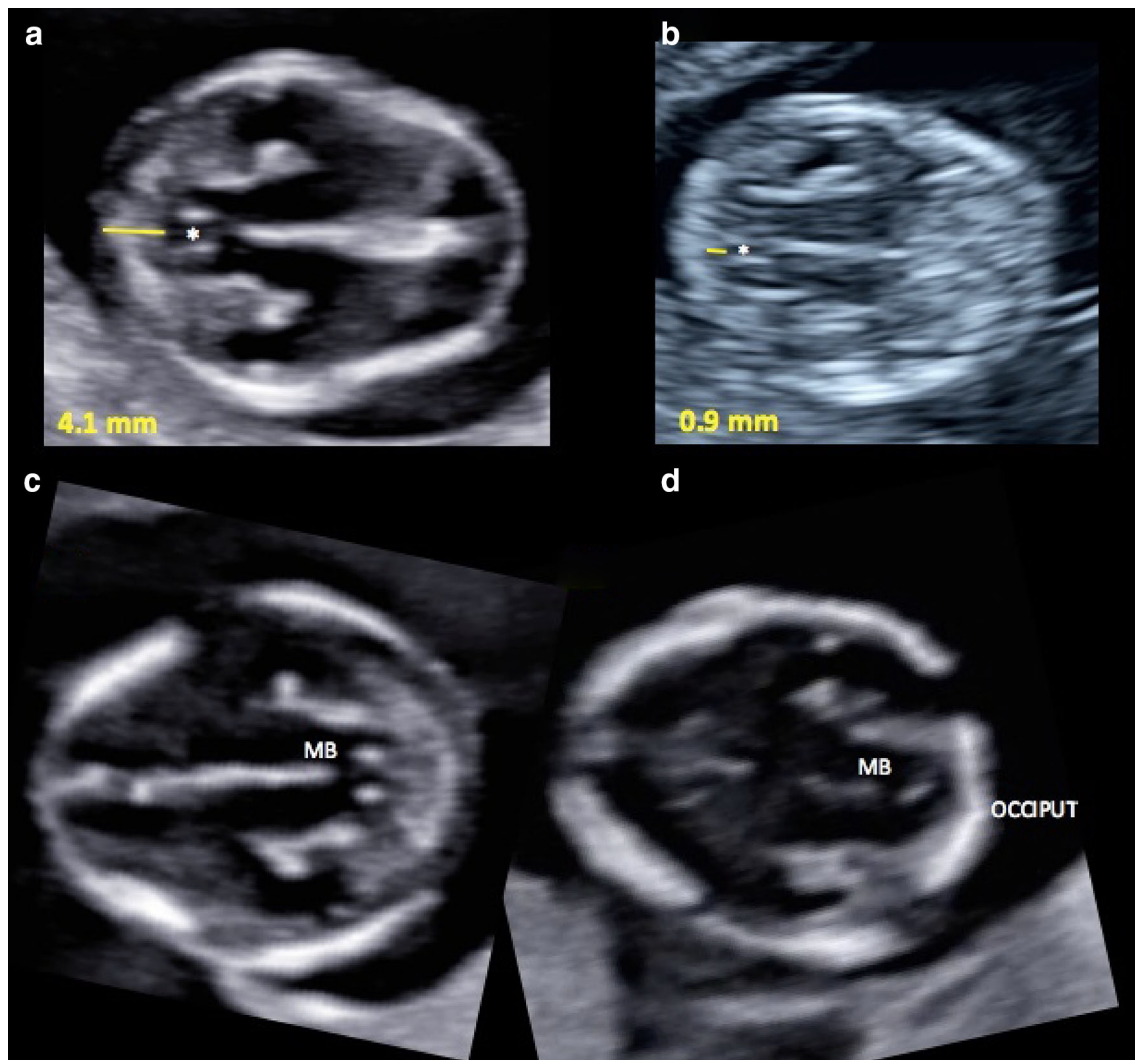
a Aqueduct of Sylvius (AOS)—occiput distance. Axial transabdominal sonogram of head shows normal distance between AOS (*) and occipital bone in a fetus of CRL 68 mm, b Aqueduct of Sylvius (AOS)—occiput distance. Axial image shows reduction in AOS—occiput distance in a fetus with myelomeningocele at 12 weeks due to leakage of cerebrospinal fluid. (*) is placed within
